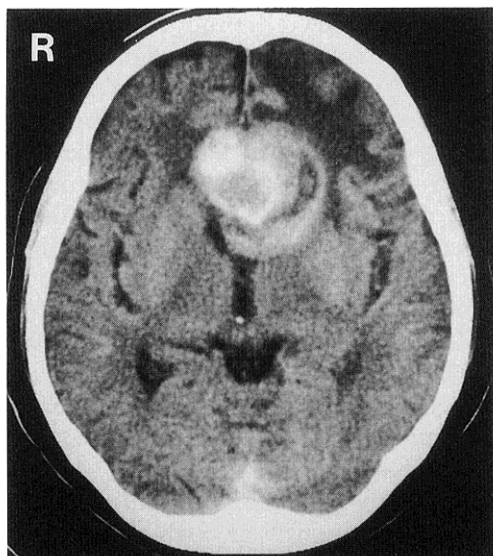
Computed tomography scan with contrast medium demonstrating a well-demarcated, 5-cm diameters mixed density lesion with slight rim-like enhancement in the frontal interhemispheric fissure, and surrounded by severe edema.
